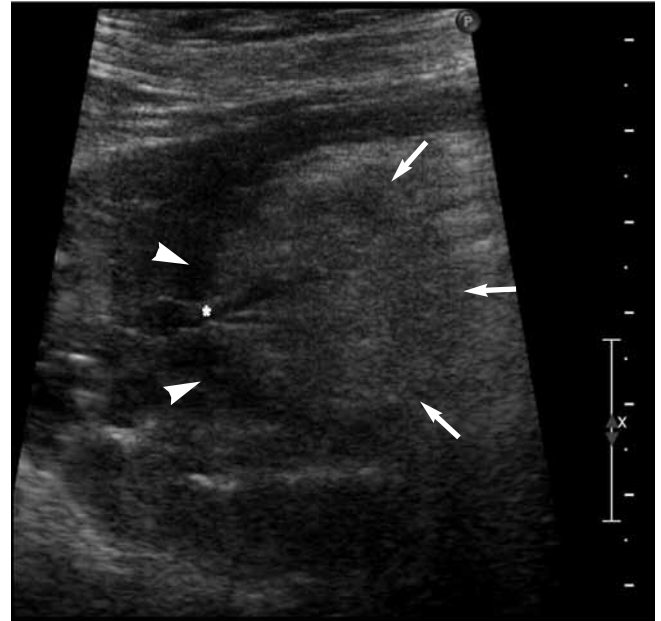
High-resolution ultrasound study reveals a 2.5 cm in diameter round mass (arrows) adjacent to a non-peristaltic thickened duodenojejunal flexure. A branched ductal system (asterisk) connected to the inferior wall of the duodenojejunal loop (white arrowheads) is well observed, confirming the diagnosis of ectopic pancreas.
